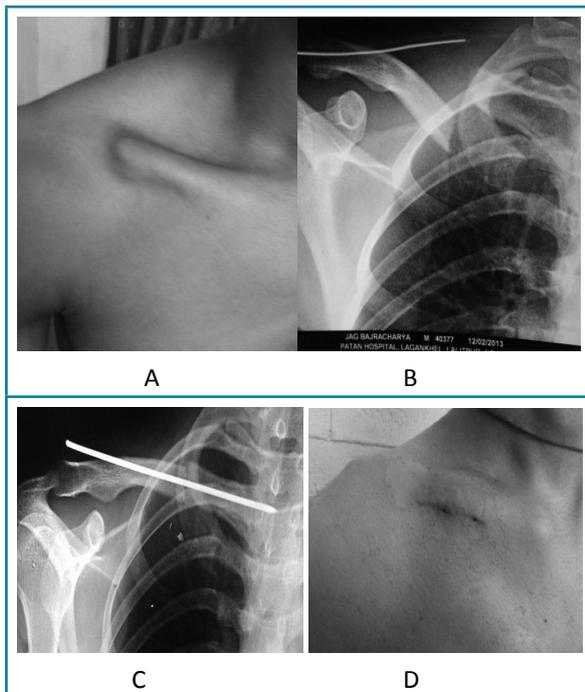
Clinical Presentation following trauma, A. Radiograph showing two part Midshaft Clavicular fracture, B. Post Operative radiograph, C. photograph of the healed wound after 2 weeks of surgery, D. radiograph following removal of K-wire shows union of fracture with bridging callus around the fracture, E.
